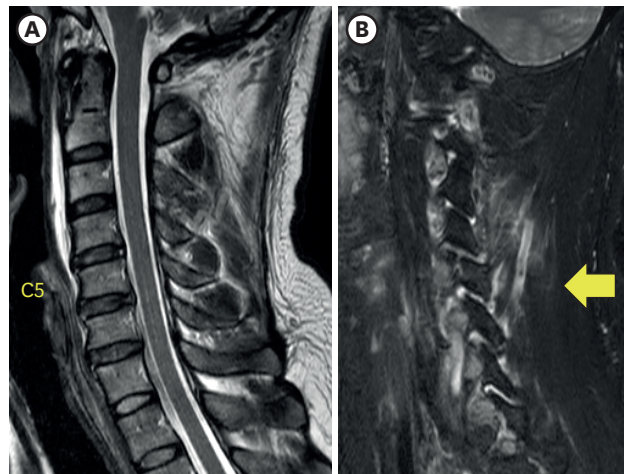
Associated injuries exhibited by magnetic resonance imaging. (A) Mid-sagittal section of cervical T2 magnetic resonance imaging showed no evidence of disc injury or herniation. Anterior and posterior longitudinal ligaments were not injured. (B) Fat saturated T2 sequence on post-trauma day 2 showed posterior ligament complex injury (yellow arrow).
